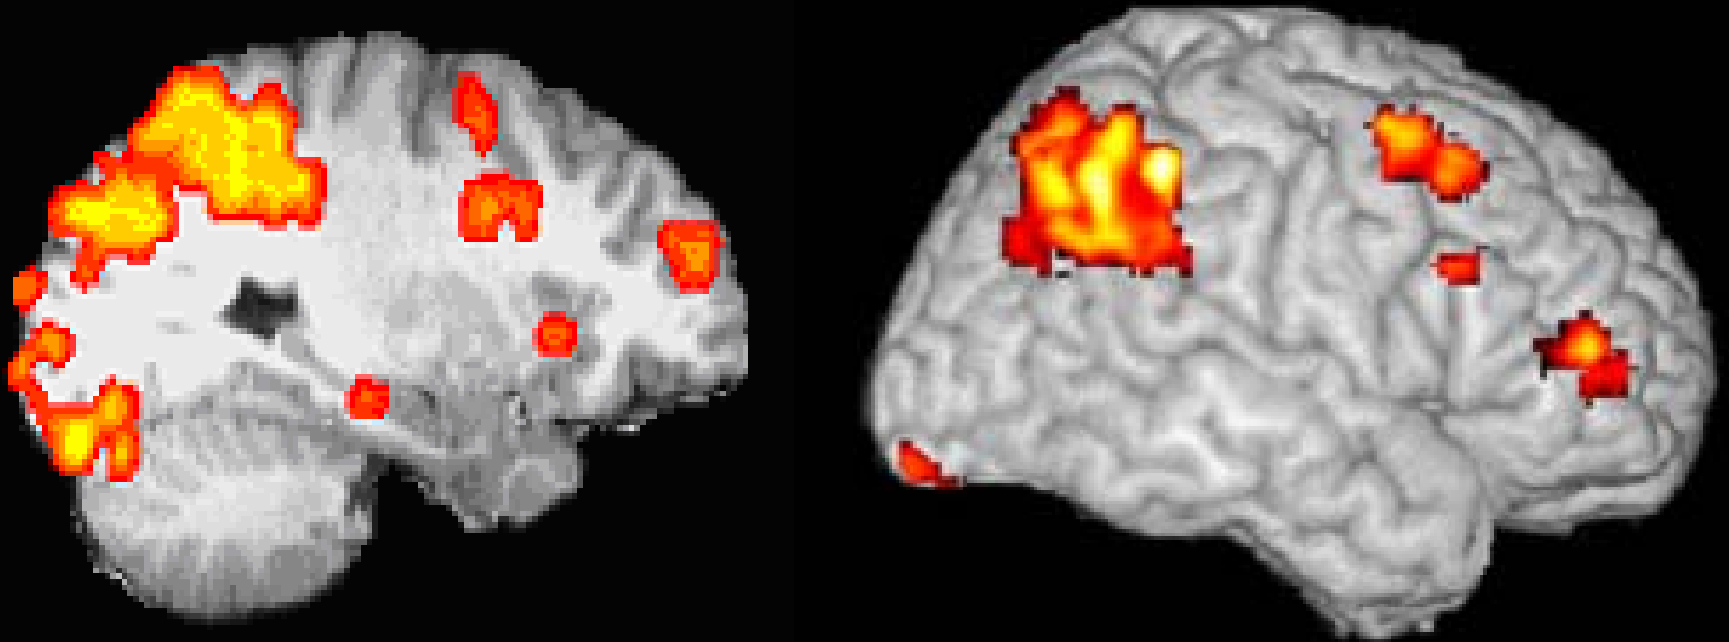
MRI - sagittal orientation
